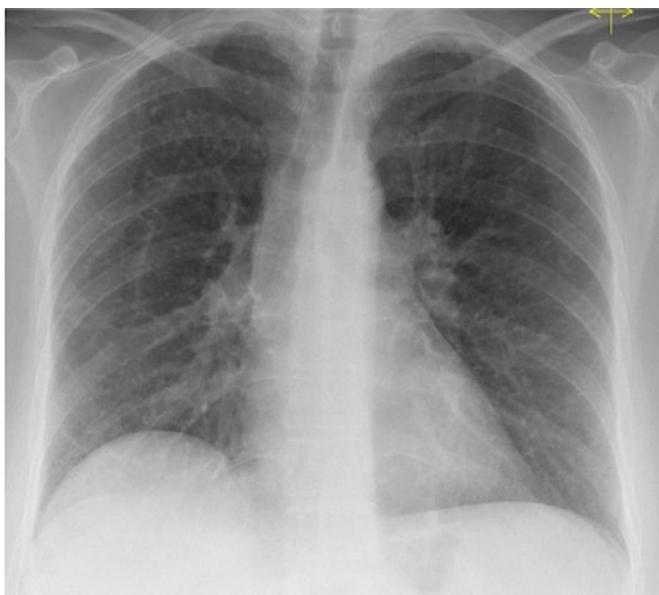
Chest radiograph demonstrates multiple tiny pulmonary parenchymal nodules throughout both lung fields but with an upper lobe predominance.
